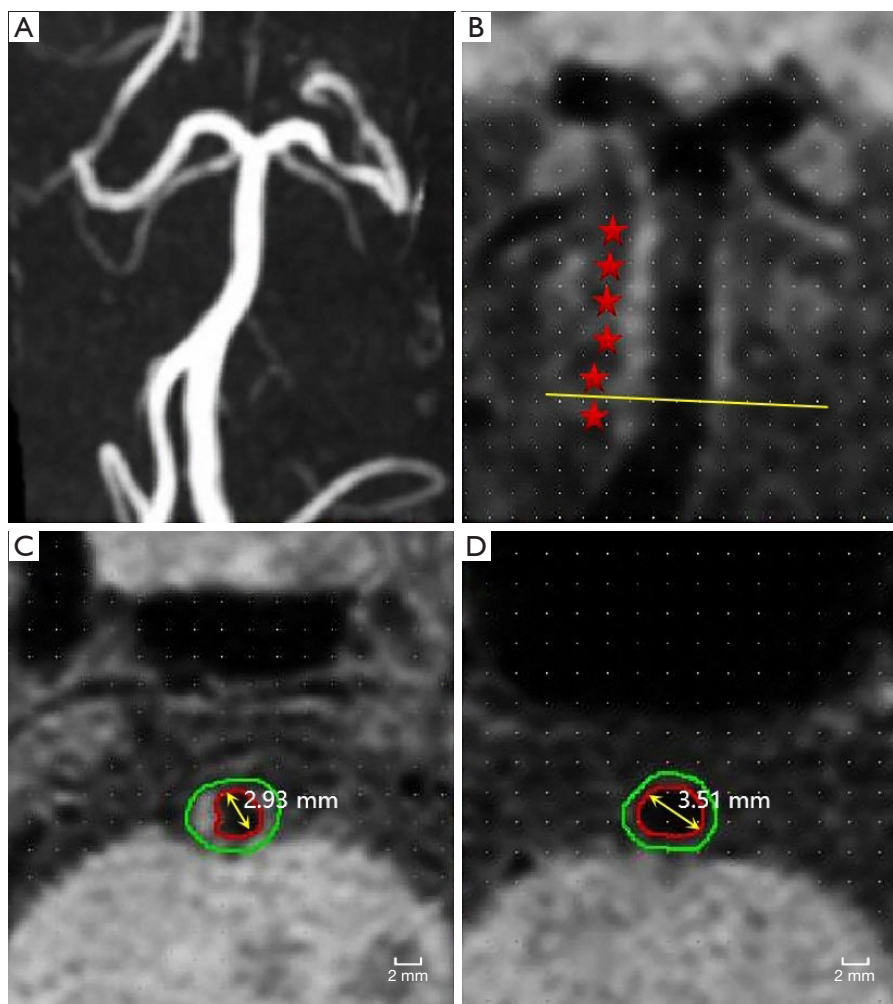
Basilar arterial PR of a patient with acute ischemic stroke. (A) MRA image of the vertebrobasilar artery of the patient. (B) Pre-enhanced 3D T1-VISTA of the basilar arterial wall reveals atherosclerotic plaque (red asterisks). The maximum narrow plane is marked by the yellow line. (C,D) A short-axis image was reconstructed perpendicular to the basilar artery, and the lumen (red) and tube wall (green) of the narrowest section (C) and the reference section (D) were manually drawn on the cross-sectional image. Calculation of vascular RI: output the data of TVA using the software automatically. RI was calculated by $RI = TVA_{\text{stenosis}} / TVA_{\text{reference}}$ with PR defined as $RI \geq 1.05$ and non-PR defined as $RI < 1.05$, $RI = 0.1844 / 0.1620 = 1.14 > 1.05$, indicating that this blood vessel is PR. MRA, magnetic resonance angiography; 3D, three-dimensional; T1-VISTA, T1-weighted volume isotropic turbo spin-echo acquisition; RI, remodeling index; TVA, total vascular area; PR, positive remodeling.
